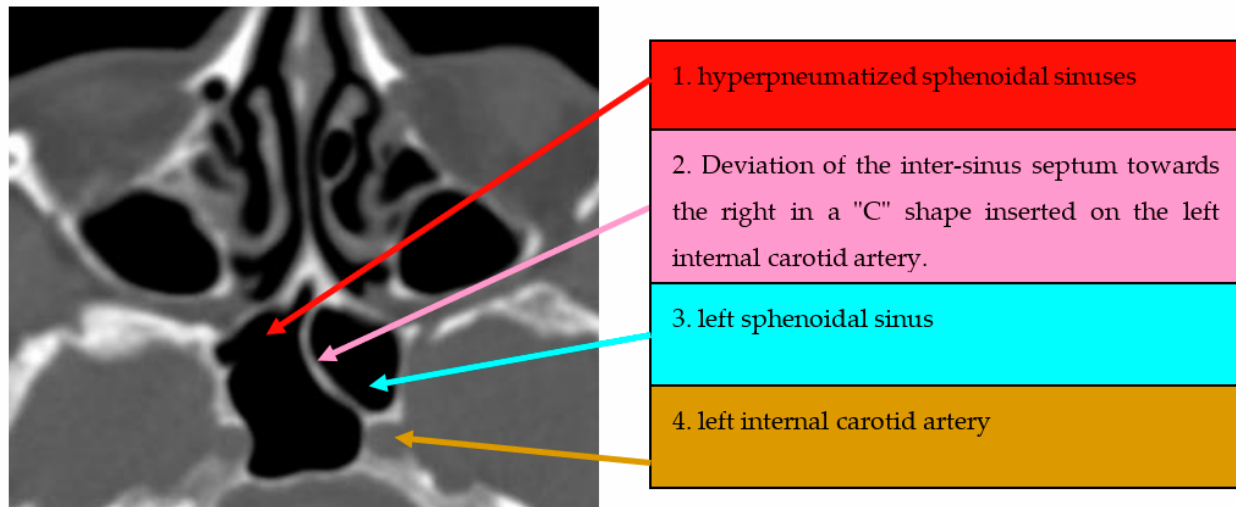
Axial CT section of paranasal sinuses with deviated intersphenoidal septum towards right, in a “C” shape, inserted on the internal carotid artery.
